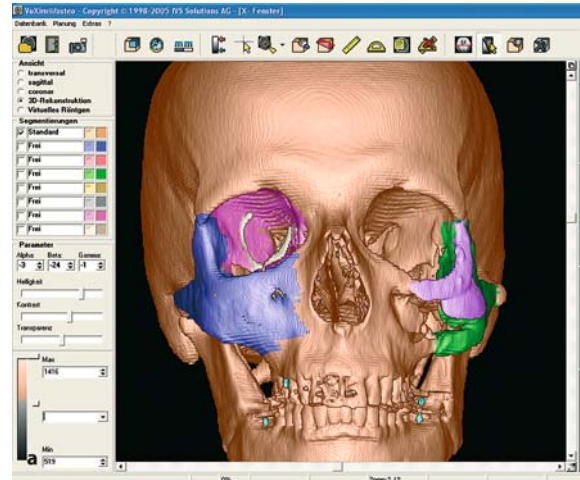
Secondary reconstruction – postoperative evaluation by image fusion. The result of the reconstruction is vividly portrayed by successively superimposing the pre- and postoperative CT data sets (from a to c)
